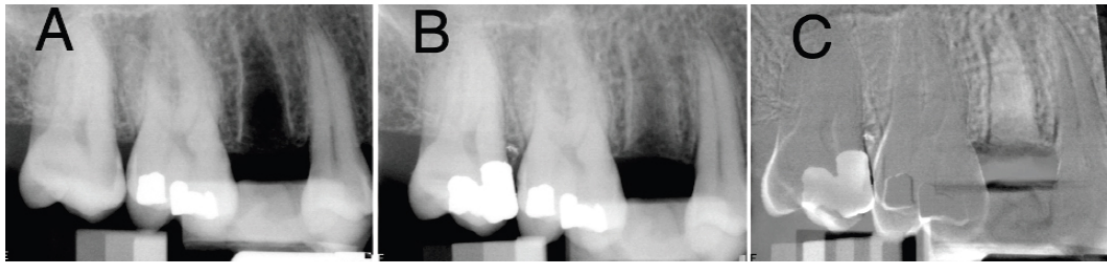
Subtraction radiography. (A) Standardized digital radiograph immediately following tooth extraction; (B) 12-week follow-up radiograph; (C) Subtracted image.
